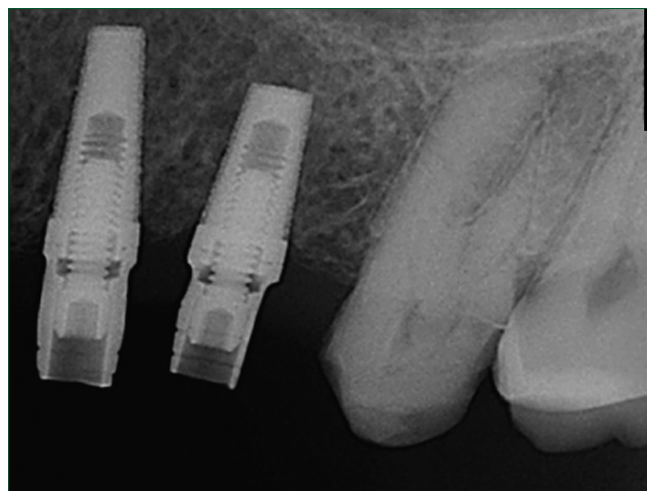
Intraoral radiograph taken immediately after abutment tightening showing the loosened 25 beaded implant and the osseointegrated 26 implant
